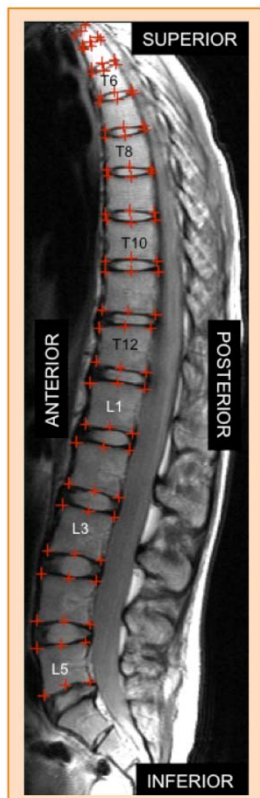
Mid-line sagittal MR image of the spine.
